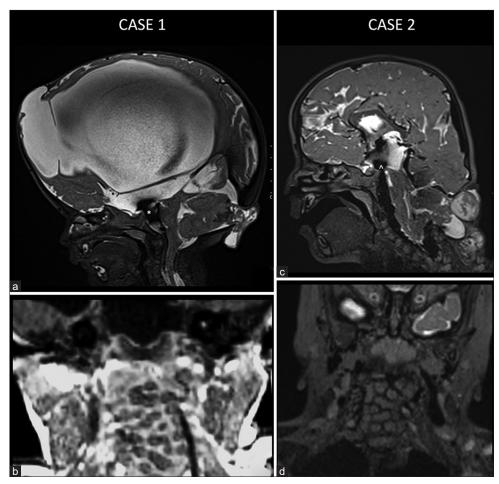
(a) Case 1 – Sagittal T2-weighted image – shows defect in occipital bone with occipital meningoencephalocele, and crowding of foramen magnum, gross hydrocephalus, and frontal leptomeningeal cyst. J shaped Sella and scalloping of clivus is also seen. Prominent flow void is noted in region of Liliequist membrane between interpeduncular cistern and third ventricle (*). (b) Case 1 – Coronal T1-weighted image revealing multiple segmentation anomalies in cervical spine. (*c*) Case 2 – Sagittal T2-weighted image revealing small posterior fossa with inferior herniation of brainstem and cerebellum along with high cervical encephalocele. Prominent CSF flow void is noted at the site of Liliequist membrane (^). (d) Case 2 – Coronal T2WI showing multiple incarcerated hemivertebrae in cervical spine.
